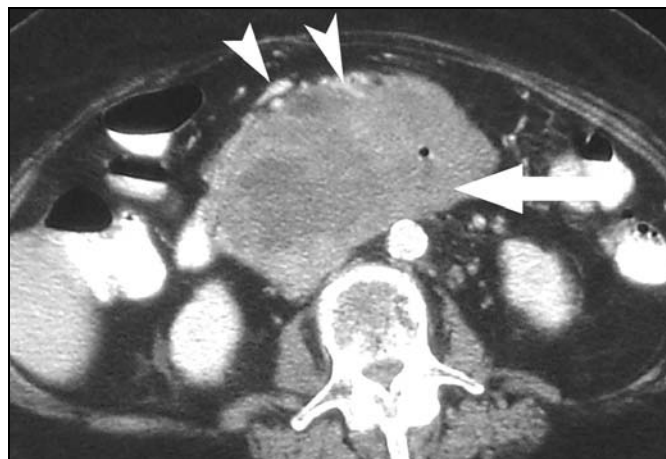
75-year-old woman with small-bowel gastrointestinal stromal tumor. Axial contrast-enhanced CT scan of mid abdomen shows large mesenteric mass (arrow) growing around mesenteric vessels (arrowheads). There is no thrombosis of mesenteric vessels.
